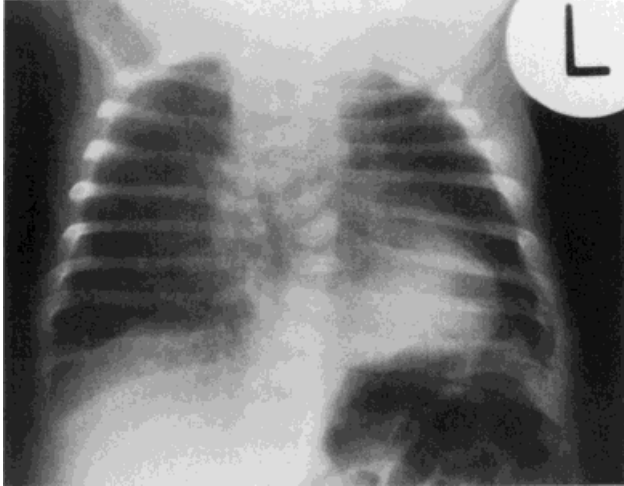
Patient 1, newborn. Frontal chest radiograph with 11 pairs of ribs. Irregularly shaped vertebrae are present with a thoracic levoscoliosis. Scapulae are hypoplastic.
